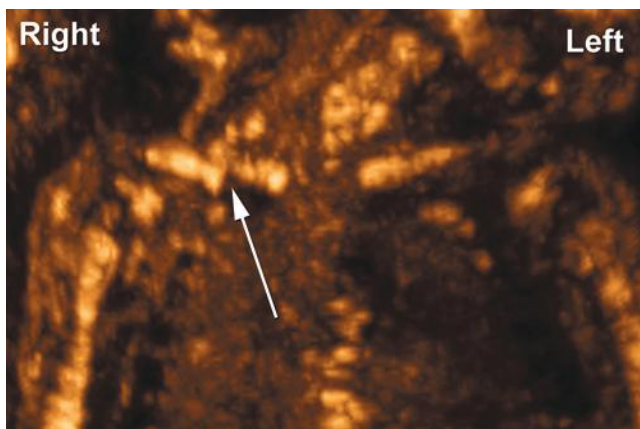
Three-dimensional ultrasound-rendered image of the fetal shoulders using the maximum intensity projection mode in a fetus with cleidocranial dysplasia. The arrow points to a site of pseudoarthrosis (fracture) of the clavicle (From Soto E, Richani K, Goncalves LF, et al: Three-dimensional ultrasound in the prenatal diagnosis of cleidocranial dysplasia associated with B-cell immunodeficiency. *Ultrasound Obstet Gynecol* 27:574, 2006.)
